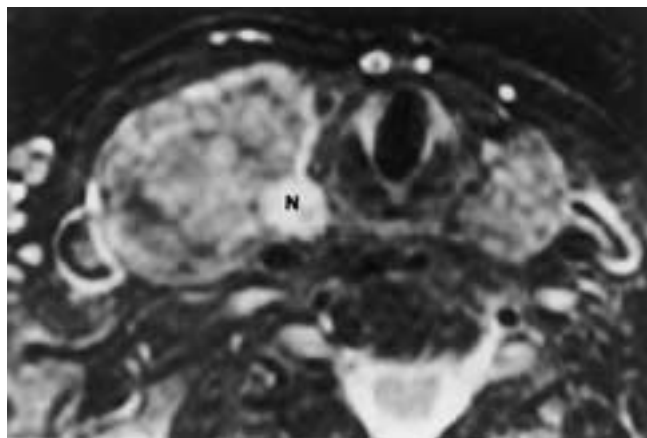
Mucoepidermoid carcinoma of the thyroid gland in a 76-year-old woman with a long-standing history of goiter. Axial fat-suppressed T2-weighted image shows diffuse goiter. A 1 cm hyperintense nodule (N) was biopsied and shown to be mucoepidermoid carcinoma.
